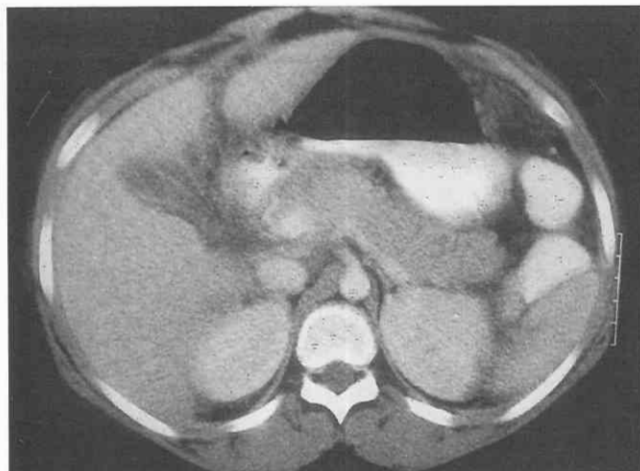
Acute pancreatitis with pancreatic enlargement and ill-defined borders. CT scan through the pancreas in a patient with acute pancreatitis demonstrates diffuse pancreatic enlargement. There are ill-defined pancreatic margins secondary to peripancreatic inflammation.
